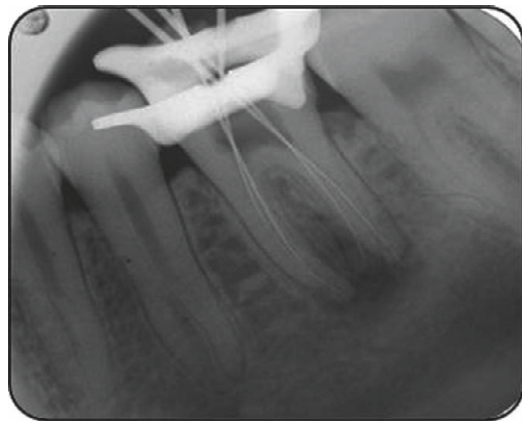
Working length radiograph of mandibular left first molar.
